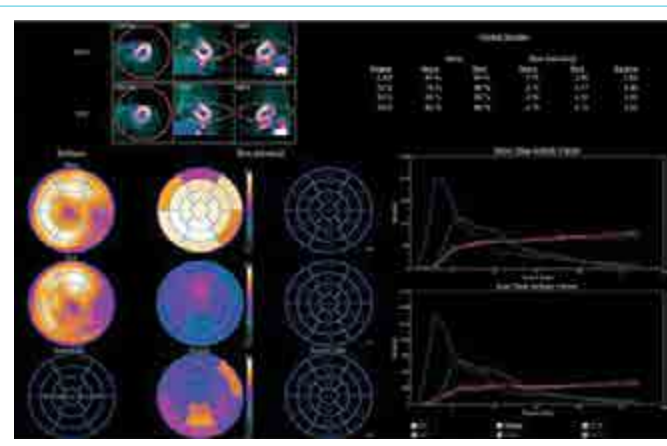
The dual-phase camptothecin was performed during 5 min of ice cube emersion for the stress phase and at rest to underpin the physiological changes of the left ventricular reserve flow being evaluated by the ^{82}Rb PET-CT. Utilizing the acquisition of the list mode CT in static and dynamic phases to reconstruct CT images for attenuation correction and the dynamic data acquisition were processed to obtain the quantification value of VFR of the left ventricle using FlowQuant software (Ottawa, Canada) on the PET polar map
